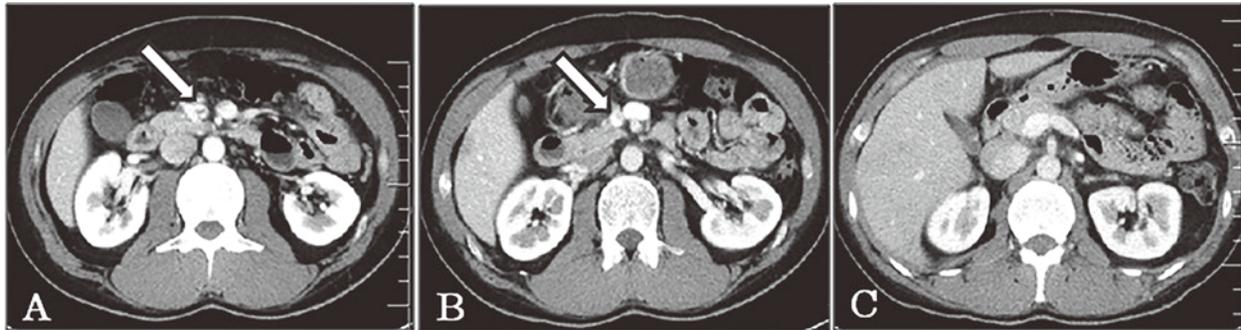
Follow-up computed tomography with contrast enhancement after treatment
